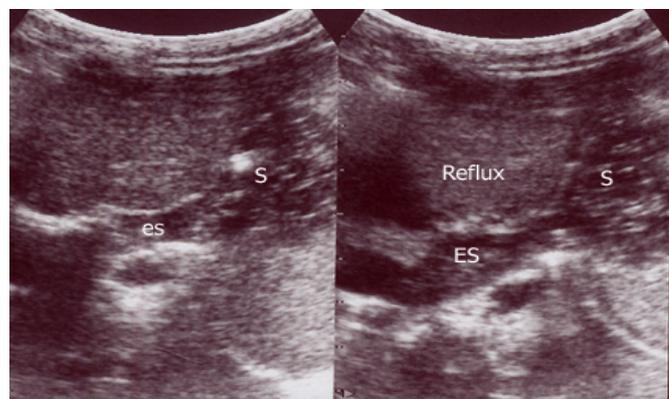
Reflux in sonography, ES=esophagus, S=stomach
